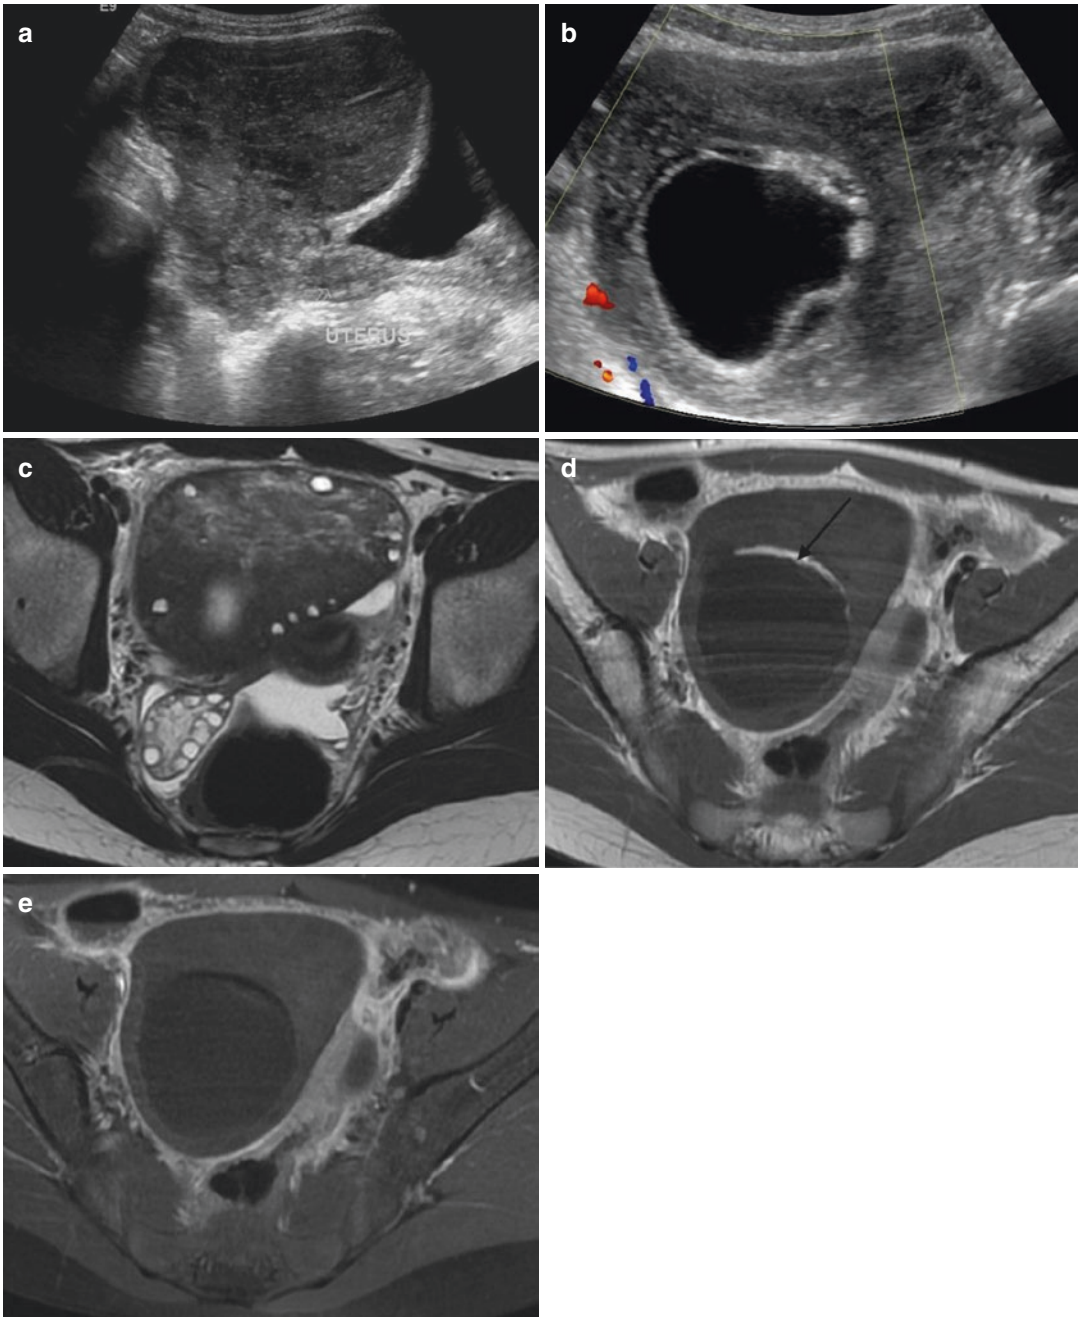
Adnexal torsion in a 13 year-old girl with underlying benign cystic teratoma. (a) US Sagittal view: Large parauterine mass with follicles. (b) US Axial view: Central cystic component with a hyperechogenic crown. (c) MR imaging: Axial T2-Weighted sequence. Significant asymmetry of size of the ovaries and medialization of the left adnexa. Note the pelvic effusion and the displacement
